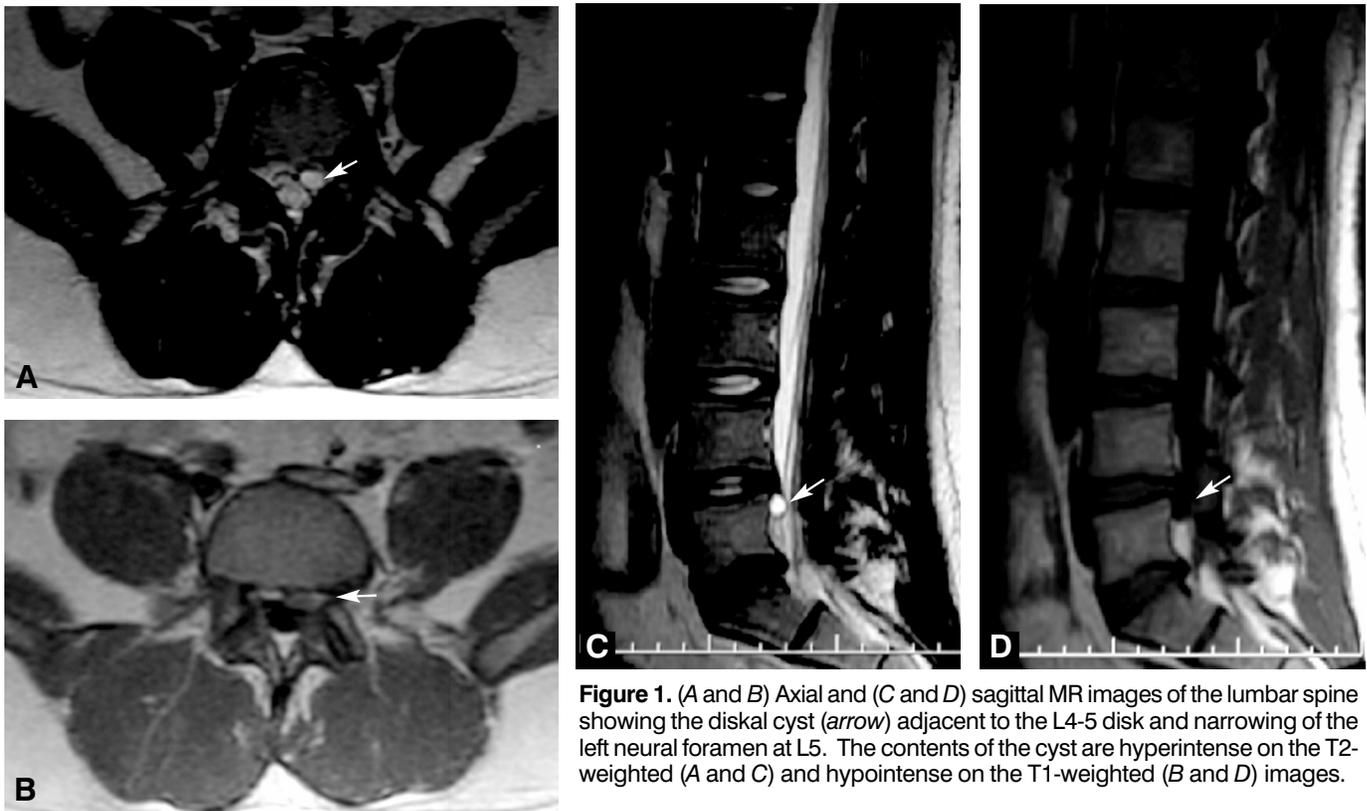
(A and B) Axial and (C and D) sagittal MR images of the lumbar spine showing the diskal cyst (arrow) adjacent to the L4-5 disk and narrowing of the left neural foramen at L5. The contents of the cyst are hyperintense on the T2-weighted (A and C) and hypointense on the T1-weighted (B and D) images.
